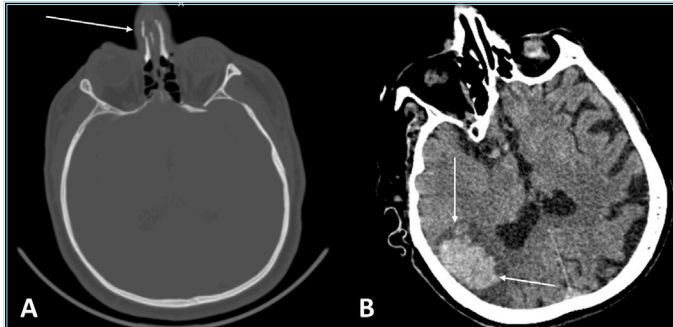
Nasal fracture and intraparenchymal hemorrhage. A) The image on the left is an axial CT scan of a patient admitted to our hospital with beatings and punishments. The image shows a nasal fracture (arrow). B) The image on the right is a CT scan of a patient admitted with the occupant ejected from the motor vehicle. The image shows intraparenchymal hemorrhage (arrows) and edema
